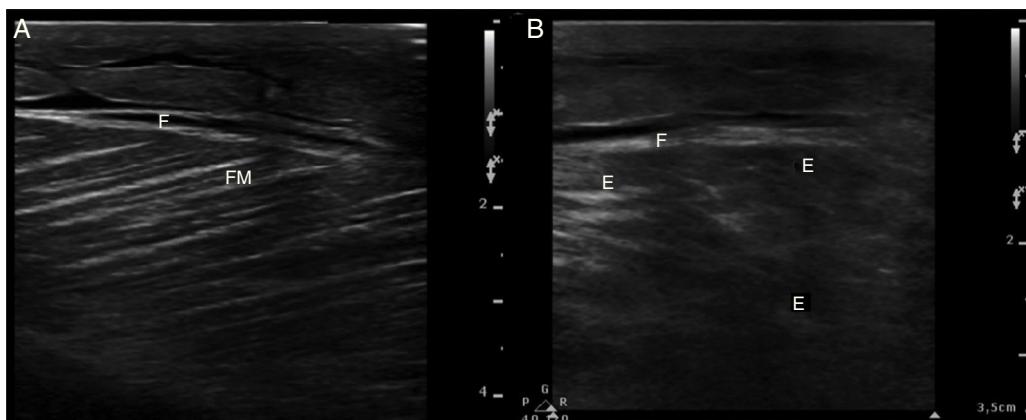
(A) Ultrasound image in 2D mode, longitudinal section of the left rectus femoris muscle of a healthy patient, showing muscle fascia (F) of preserved diameter and muscle fascicles (MF) distributed obliquely and evenly, characteristic image in "bundles of straw". (B) Ultrasound image of the left rectus femoris muscle with rhabdomyolysis, showing muscle fascia thickening (F), loss of orientation of the muscle fascicles with reduction of echogenicity and anechoic areas (E).
